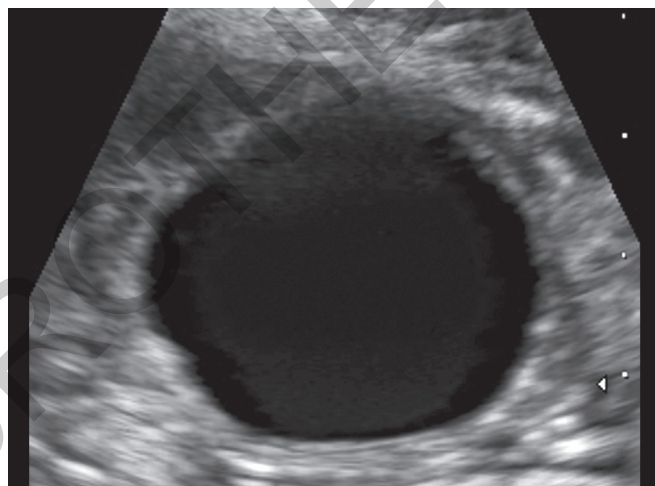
B-mode ultrasound image of a mature follicle.
